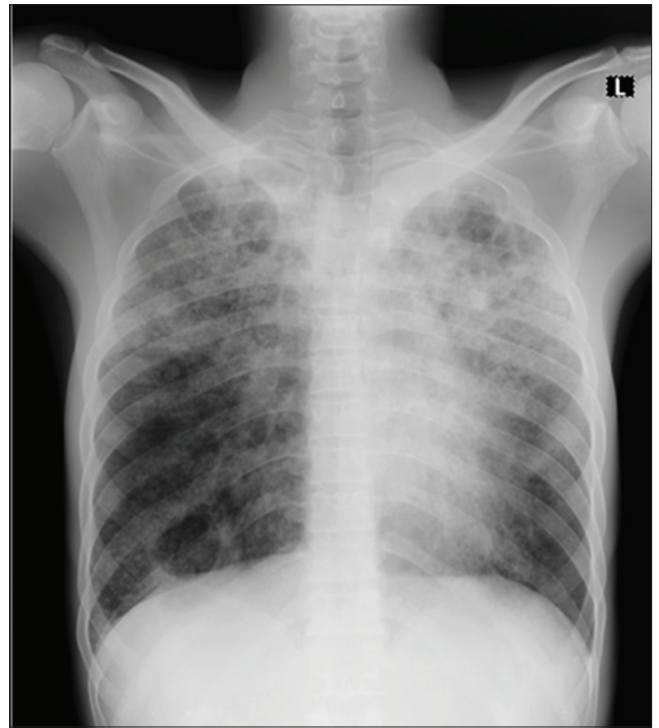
Radiographic changes in patient one
